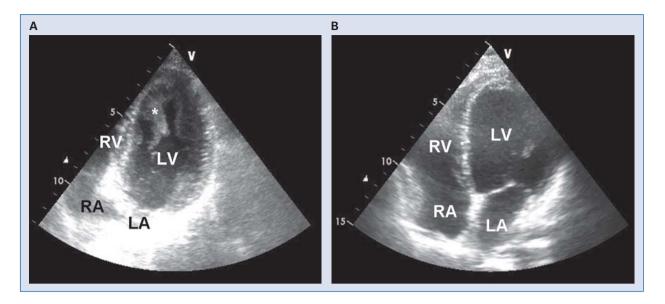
A. Transthoracic echocardiography shows a polypus mass attached to the apex of the left ventricle (LV), floating freely during cardiac cycle; B. No evidence of intracardiac mass recurrence at two-dimensional transthoracic echocardiography at ten month follow-up; RV — right ventricle; LA — left atrium; RA — right atrium.
